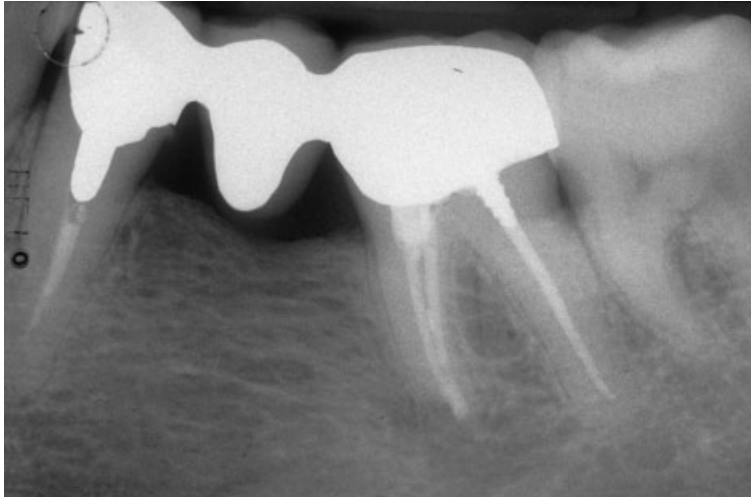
The radiographic appearance after 5 years.
